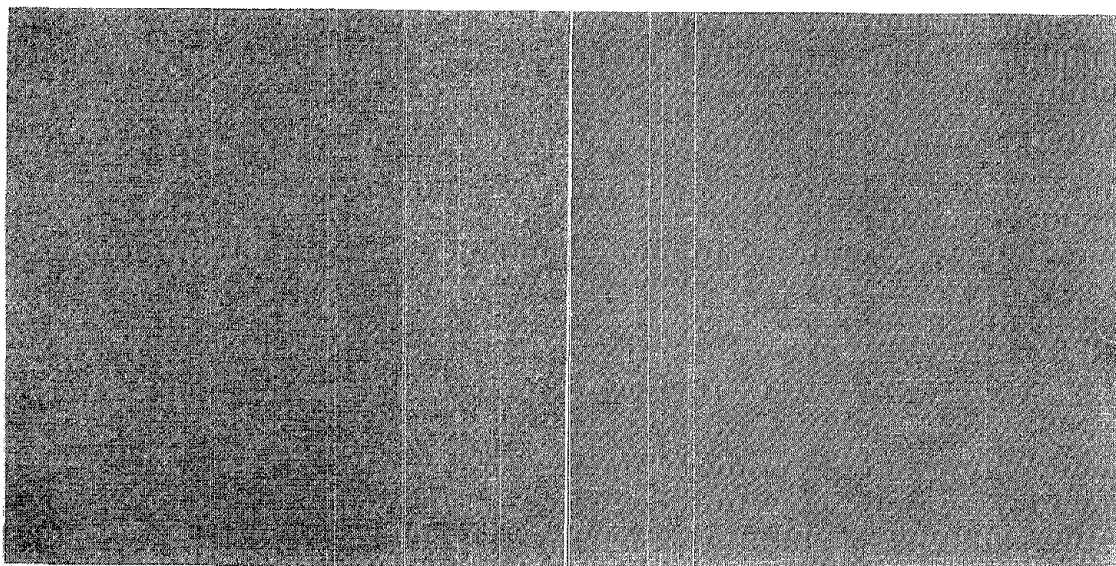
Mottle and graininess. Figure 1A (left): Radiographic mottle. This image was produced by a screen/film combination which was given a uniform x-ray exposure. The mottling or irregular density pattern is due primarily to quantum mottle. Figure 1B (right): Film graininess. This image was produced by uniform exposure of the film to light alone, without intensifying screens.
